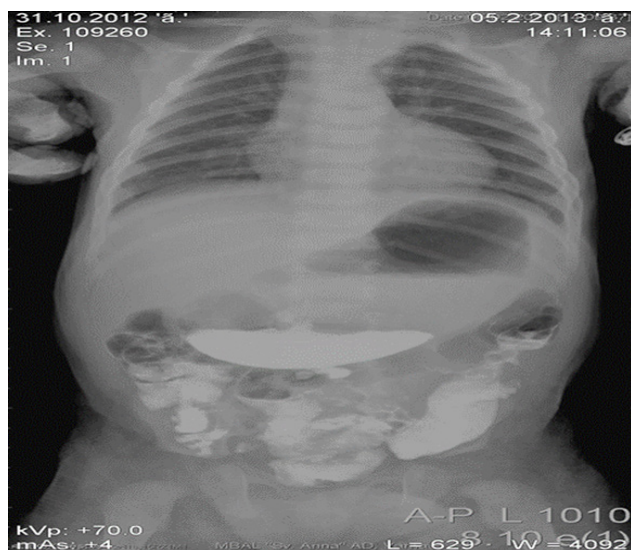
X-ray of the dilated stomach with the presence of contrast material from the previous examination.
